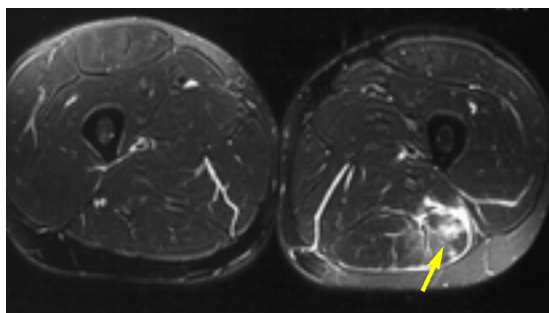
Axial MRI scans of both thighs showing increased muscle oedema in the left biceps femoris consistent with strain of the muscle (arrow). Clinically, this patient had a grade 2 left biceps femoris strain.
